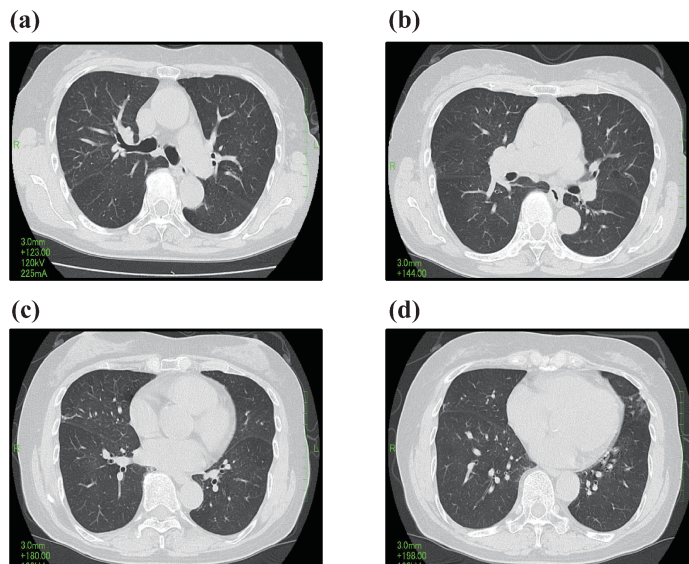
Computed tomography of the chest 7 months after environmental intervention
